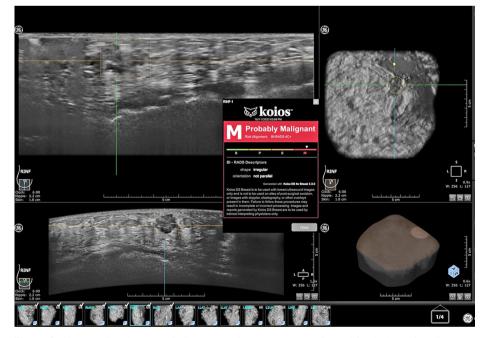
Using machine learning, a high suspicion determination was obtained for the lesion based on breast ultrasound imaging.
